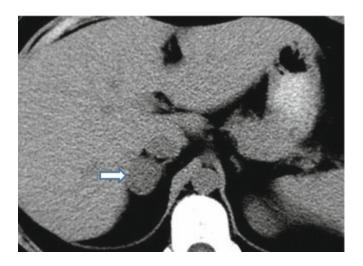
Non-enhanced abdominal CT showed an incidental right-sided, oval-shaped, well-demarcated, homogeneous adrenal mass (*arrow*), with low density (5–7 HU). This suggests high lipid content characteristic of adrenal adenoma. In the absence of extra-adrenal malignancy, the risk that it is a malignant lesion is very small
